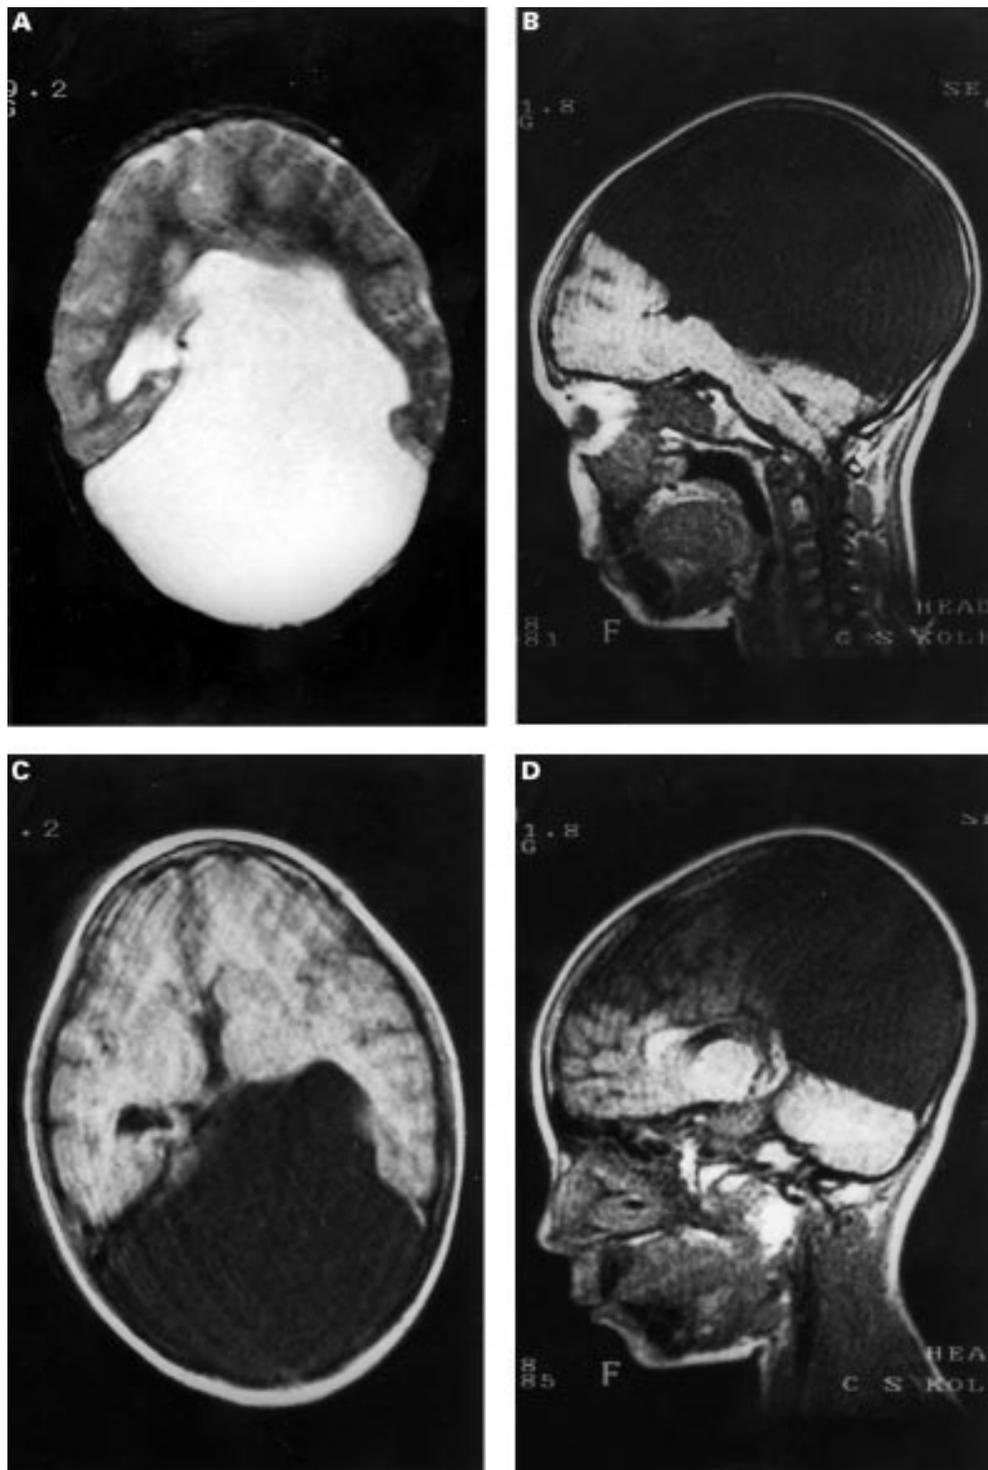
MRI scan of the patient. (A) Large CSF space communicating with the left lateral ventricle and underdevelopment of the parietal lobes. (B) Compression of the posterior fossa; note lack of cerebellar atrophy. (C) Decreased size of the frontal lobes and narrow frontal horns of the lateral ventricles. (D) Partial defect of the corpus callosum.
